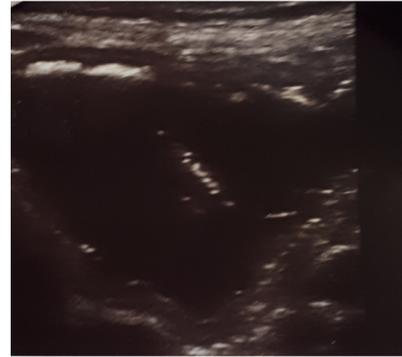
Abdominal ultrasound scan of patient. Results suggested that the foreign body was in the stomach.
